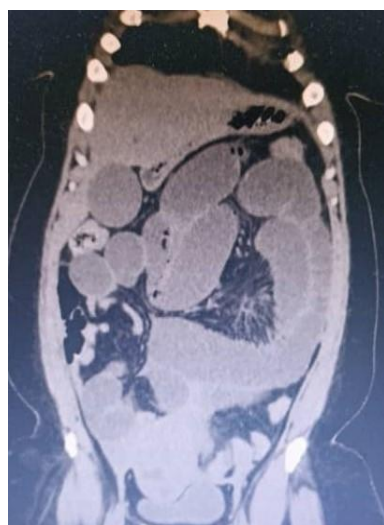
Abdominal-pelvic CT scan, coronal section: distension of the gallbladder with a transition zone at pelvic level.
